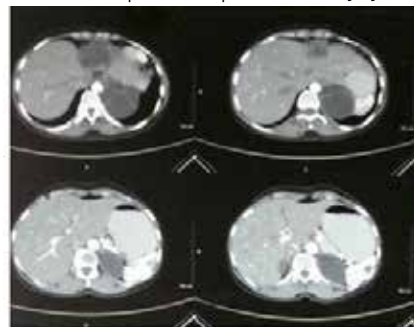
CT abdomen - hydatid cyst in liver, spleen and kidney.
